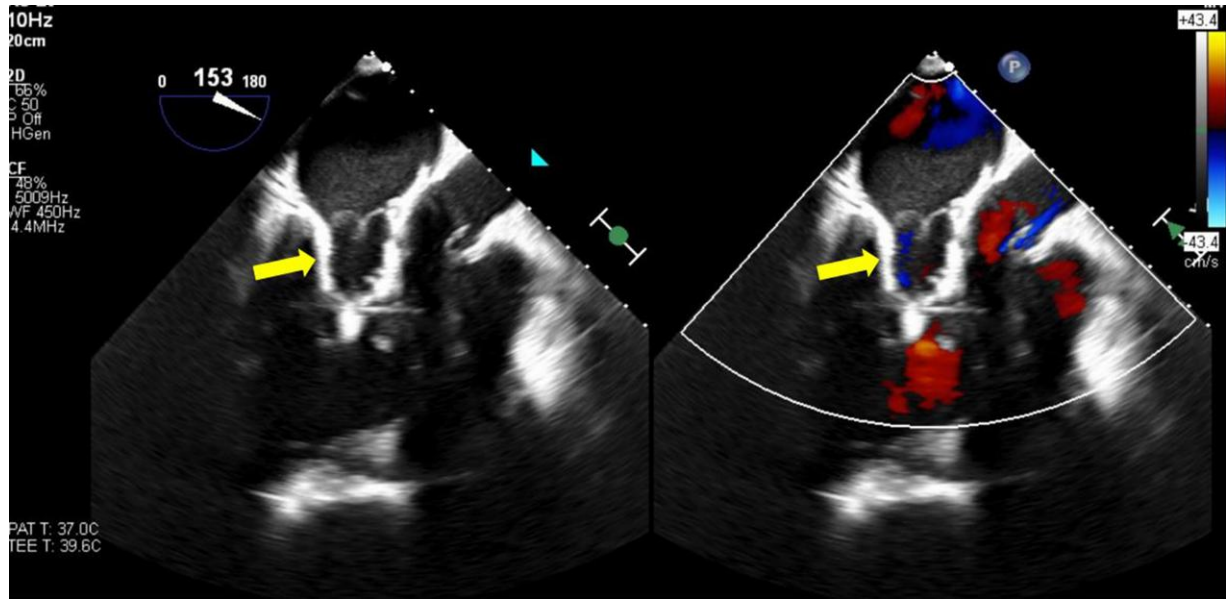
Transoesophageal echocardiography showing MitraClip detached from the posterior mitral valve leaflet (yellow arrow).
